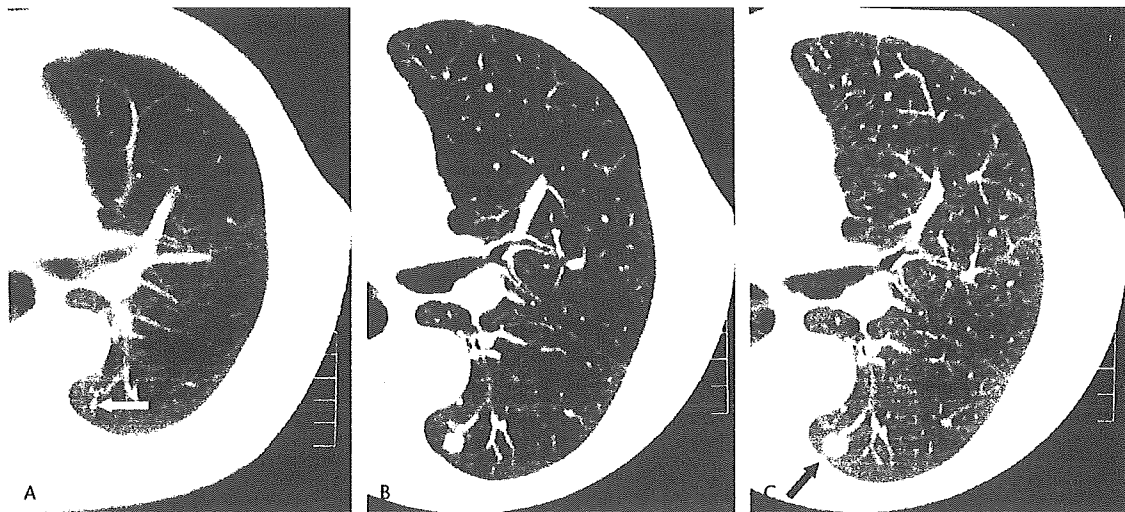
Computed Tomographic scan. A, The tumor appears as a tiny (4 × 4 mm) lesion in the periphery of the superior segment of the left lower lobe, which was identified retrospectively on a conventional CT image taken 3 months prior to that shown in (B). White arrow points to the tiny lesion. B, In this high-resolution CT (HRCT), the solid nodule was first recognized as a 9 × 9 mm sized, homogeneous one of soft tissue density with well-defined margin. C, Further growth of the lesion with additional pleural tag formation on HRCT taken 1 month after the image displayed in (B) following a 1-month course of anti-fungal treatment. Arrow shows the pleural tag.
